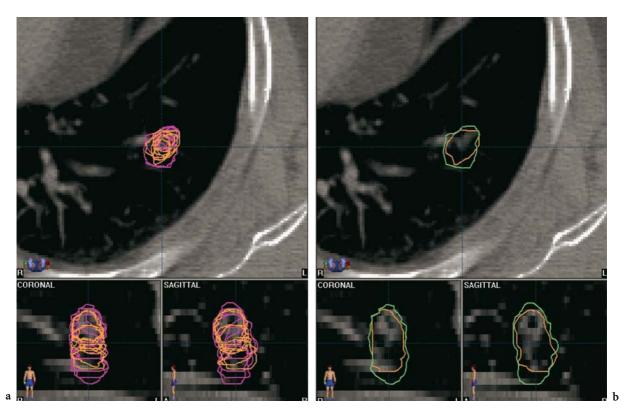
a A comparison of GTVs derived using six rapid CT scans (yellow contours) and all ten bins from a 4D CT scan (pink contours) in a highly mobile tumor. b Corresponding ITVs from six scans (yellow) and a 4D CT (green contour).
